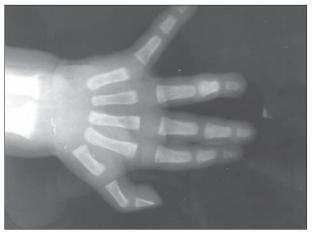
Radiography of the left wrist in our patient. There is metaphyseal fraying and cupping of the distal radius and ulna.
